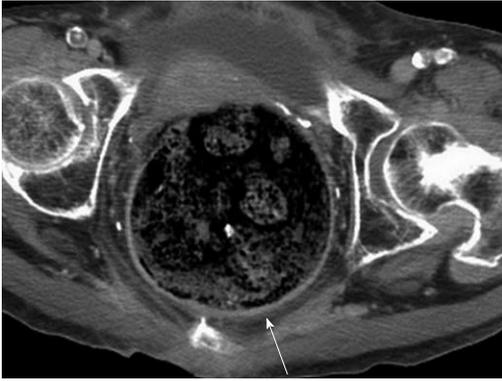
A 70-year-old woman (patient 6) with necrotic stercoral colitis. The computed tomography scan revealed stool impaction and distension of the rectosigmoid colon with asymmetrical wall thickening at the posterior aspect (arrow).
